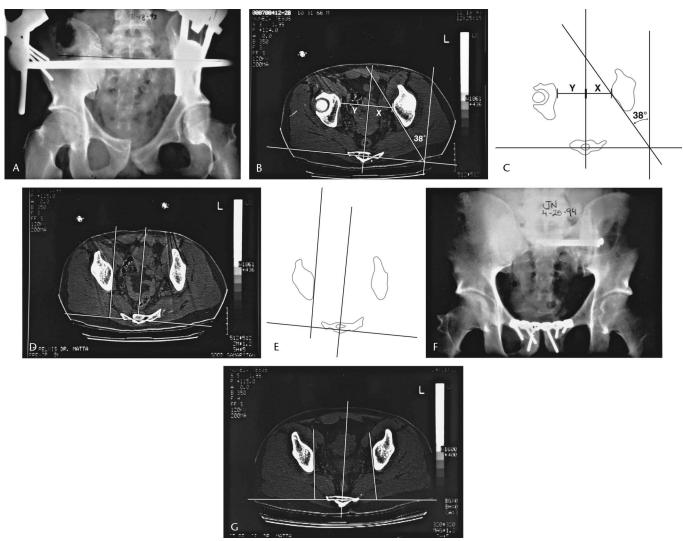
A–G, Pedestrian who sustained a left sacroiliac dislocation and symphysis diastasis (case 7; Table 1) from Figure 1. A, AP radiograph of the pelvis after application of external fixator. Notice the internal rotation of the left hemipelvis (widening of the ischium) and the widening of the sacroiliac joint posteriorly while closing the symphysis anteriorly. B, CT scan axial section showing 38 degrees of internal rotation of the left hemipelvis. C, Artist's rendition of (B) with an internal rotation deformity at 38 degrees. Available as additional information on this study is the decreased distance from the quadrilateral plate to the midline on the injured (X) as compared with the uninjured (Y) side, which suggests the presence of an adduction deformity or a medial impaction of the injured hemipelvis. D, CT scan axial section showing the uninjured right hemipelvis having internal rotation of 1 degree. In this patient, the pelvis was not perfectly perpendicular to the CT scanner gantry. Therefore, a different CT scan axial section was required for measuring the uninjured side. E, Artist's rendition of (D) showing internal rotation of 1 degree on the uninjured side. F, AP radiograph of the pelvis after open reduction and internal fixation. G, CT scan axial section showing an almost complete correction of the internal rotation deformity of the left hemipelvis.
